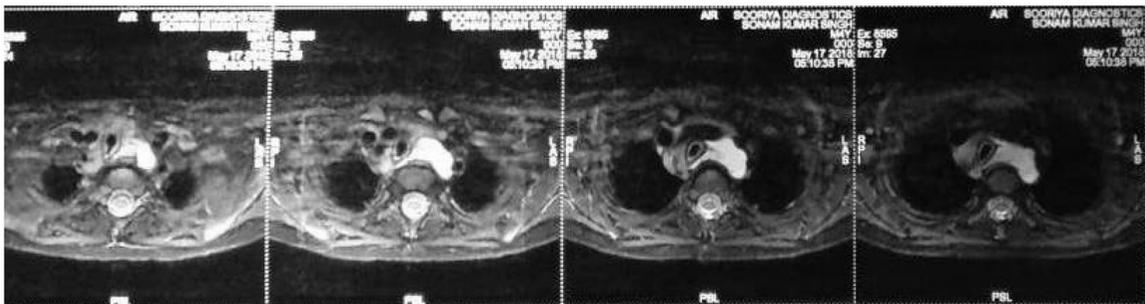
Axial imaging of MRI showing enhancing lesion around trachea and oesophagus.
